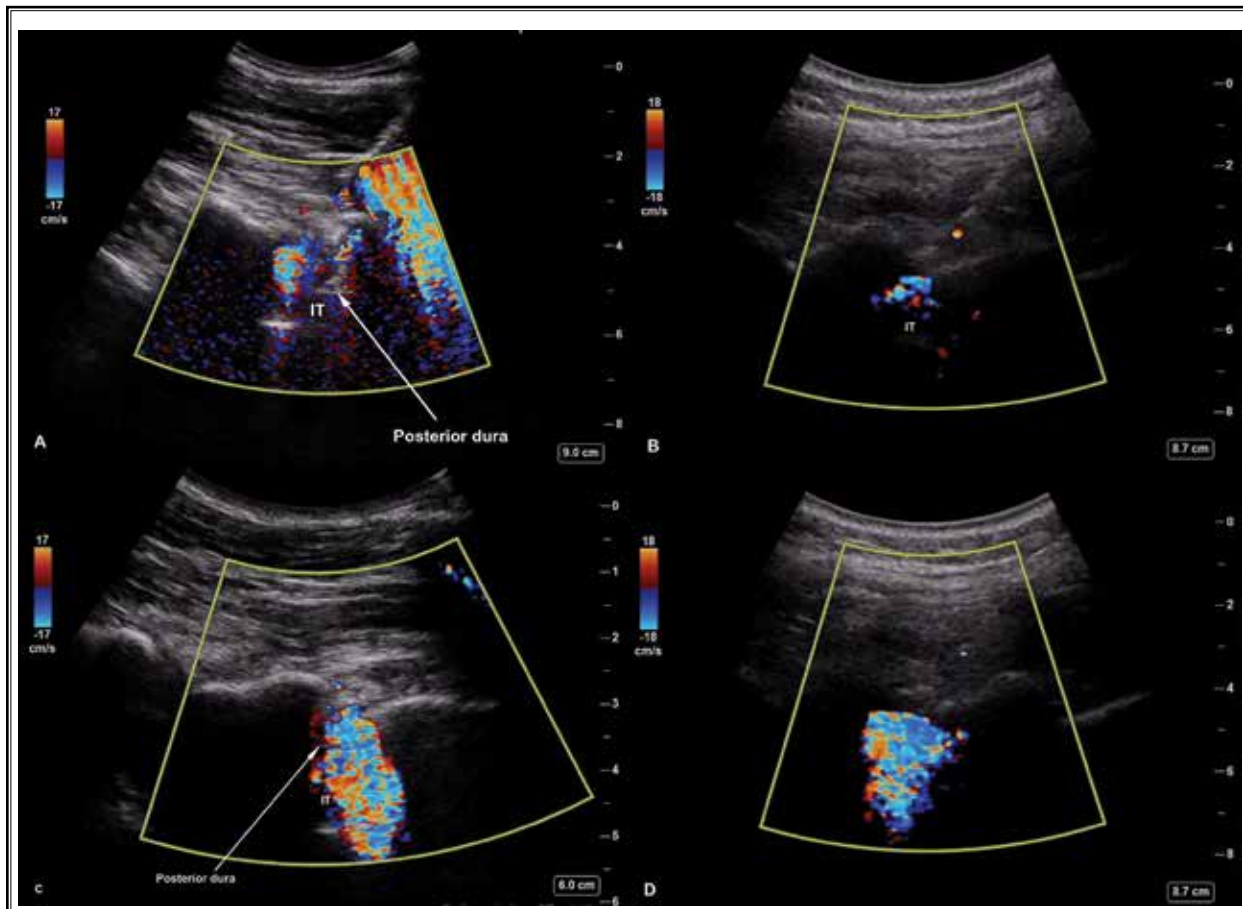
Ultrasound color Doppler image acquired during interlaminar epidural steroid injection. During drug injection, the color spectrum appears to be confined to the posterior epidural space (A,B) and around the total epidural space, including the anterior epidural space (C,D). IT, intrathecal space.
